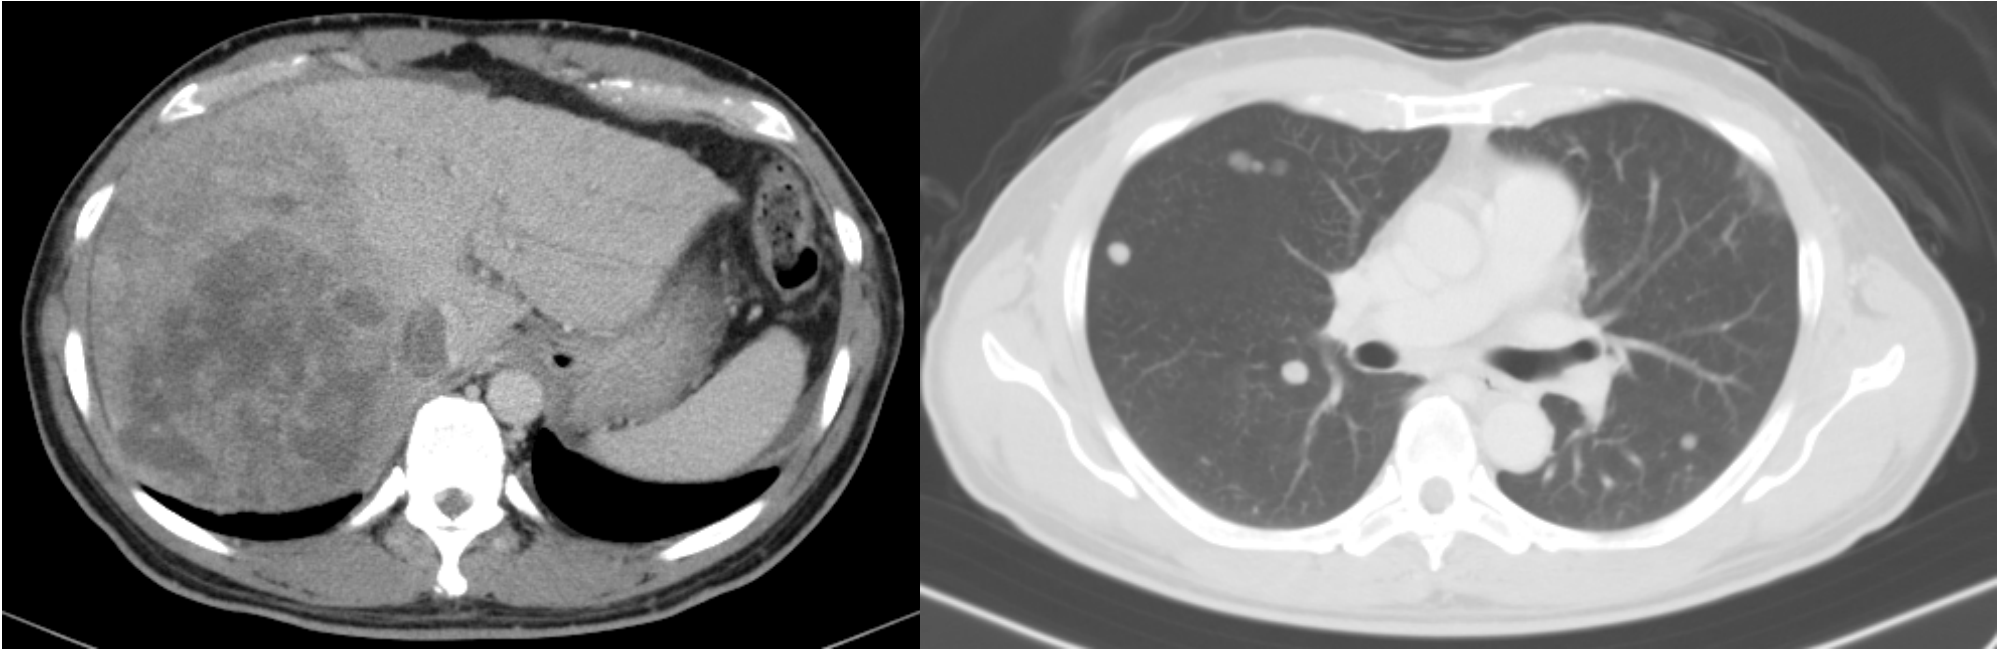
2021/07/19 CT scan : HCC with portal vein thrombosis multiple lung mets.
